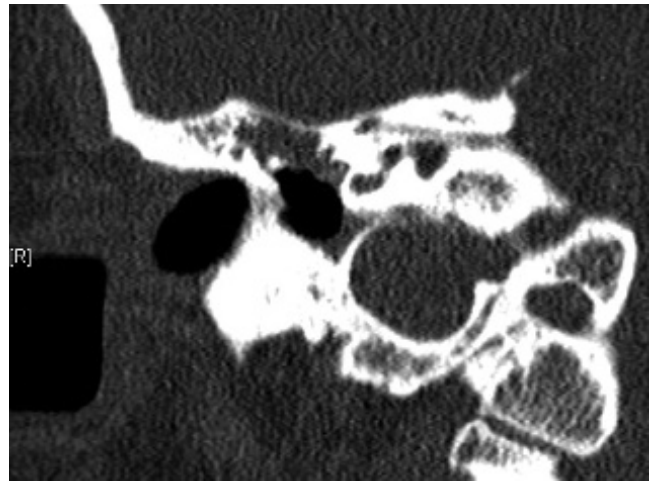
Coronal CT scan of right external ear canal showing lateral predominantly membranous atresia. The patient had undergone previous surgery for chronic otitis media.
